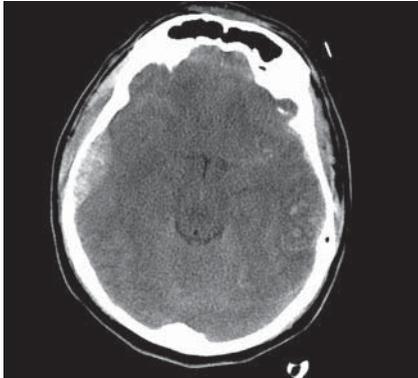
CT shows an acute right parietal epidural haematoma with a classic lens shape. Acute haemorrhage appears dense (white) on CT.
